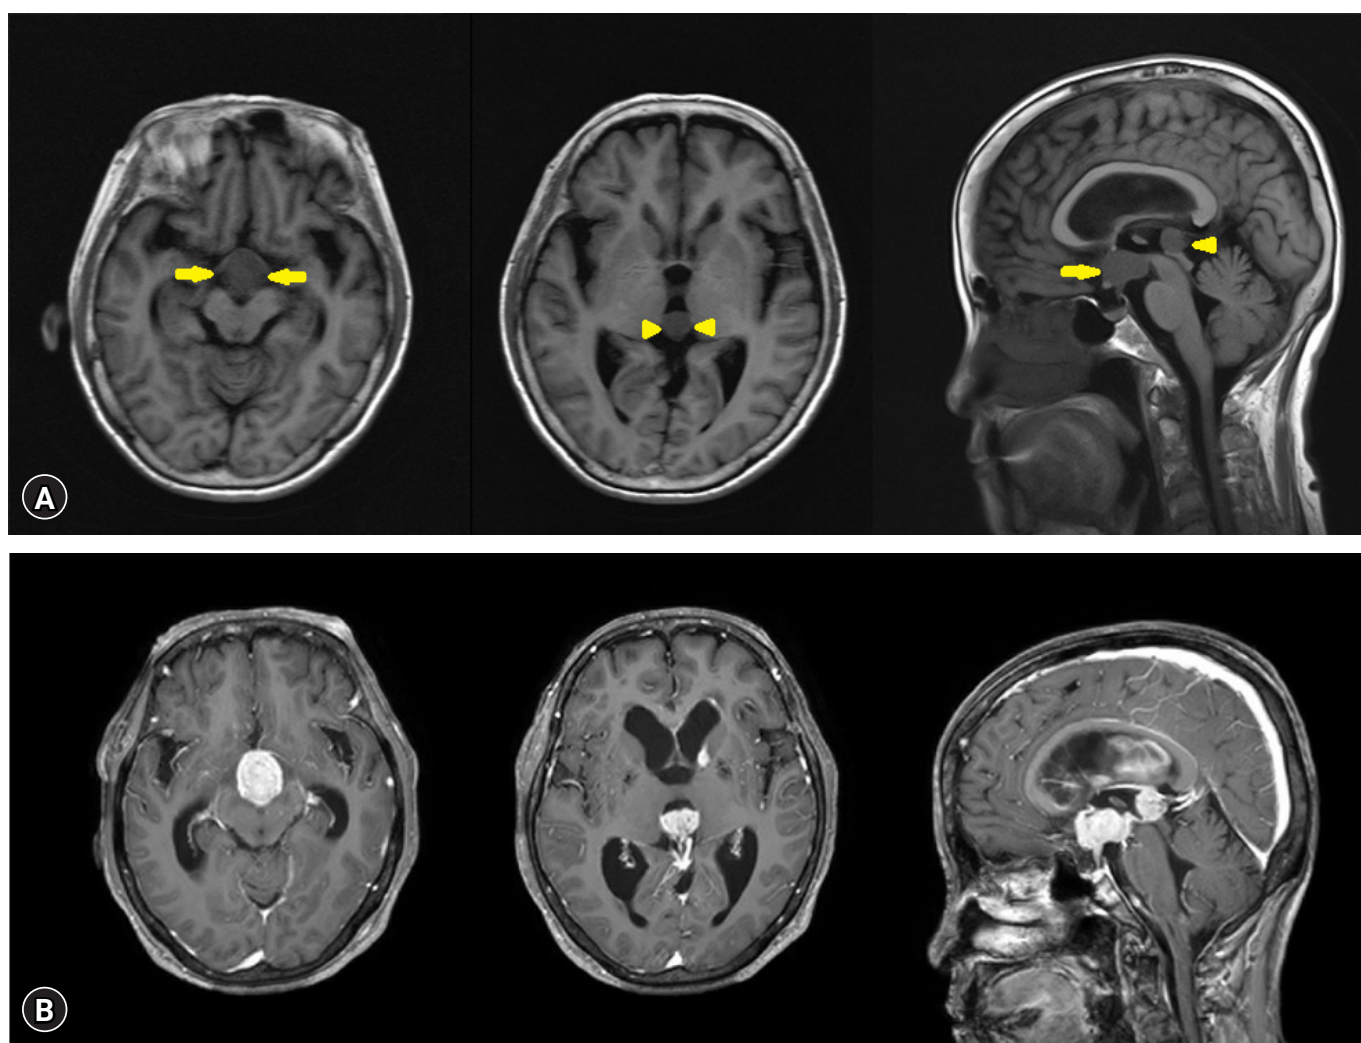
Brain magnetic resonance imaging. (A) Initial T1-weighted image (WI) without enhancement performed at outside hospital showed a suprasellar mass (2.0 x 1.8 cm size; arrow) and a pineal mass (1.2 x 1.2 cm size; arrow head) in the 3rd ventricle. (B) Gadolinium enhanced T1-WI performed 8 days later showed that suprasellar mass (2.4 x 2.1 cm size) and pineal area mass (1.7 x 1.5 cm size) increased in size, and enhancements in the left caudate nucleus, left lateral ventricle wall, septum pellucidum, pituitary stalk, anterior surface of ponto-medulla.
